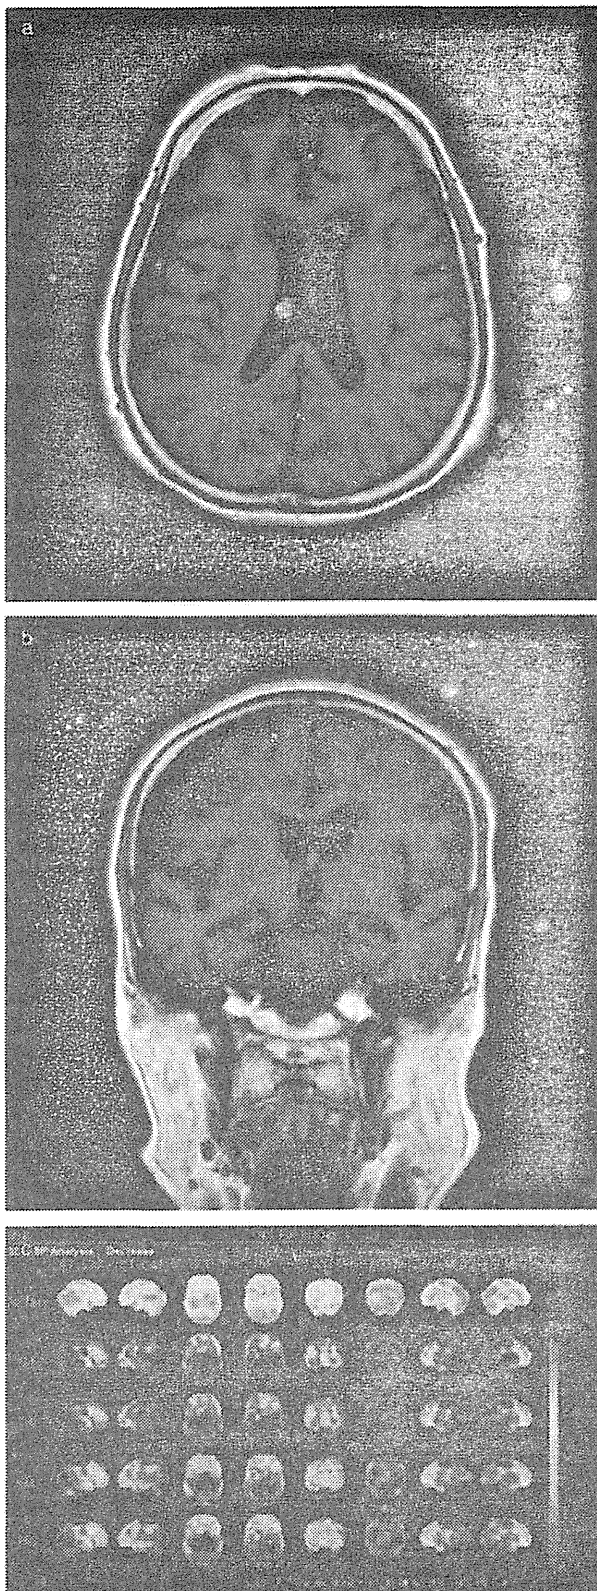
Representative neuroimaging of probable behavioral variant of major frontotemporal neurocognitive disorder (bvFT-NCD). (a) Coronal T1-weighted magnetic resonance imaging (MRI). (b) Axial T1-weighted MRI. MRI images are horizontally flipped; the observer's right is the left side of the patient's brain, and vice versa. (c) Single photon emission computed tomography imaging. Images are reconstructed using the three-dimensional stereotactic surface projection (3D-SSP) technique and superimposed on normalized images of standardized brain MRI. Color-coding represents the statistical significance (Z-score) of the decrease in regional cerebral blood flow (rCBF) in the resting mode. Red represents more significant rCBF reduction. From left to right, eight directions of the brain surface images are shown: right lateral (RT.LAT), left lateral (LT.LAT), superior (SUP), inferior (INF), anterior (ANT), posterior (POST), right medial (RT.MED) and left medial (LT.MED). Vertically from the second to the fifth lines, Z-score maps are shown (high Z-score indicates decrease): the Z-score map was normalized to the cerebral global mean (GLB) in the second line, to the thalamus (TH) in the third line, to the cerebellum (CBL) in the fourth line and to the pons (PONS) in the fifth line. The distribution of rCBF is shown in the first line (red color-coding represents increment of rCBF). The cortical atrophy shown in MRI images and rCBF reduction patterns of the 3D-SSP images are typical for frontotemporal dementia.
